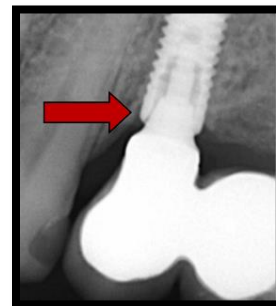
This x-ray image (red arrow) shows an implant-abutment misfit.
